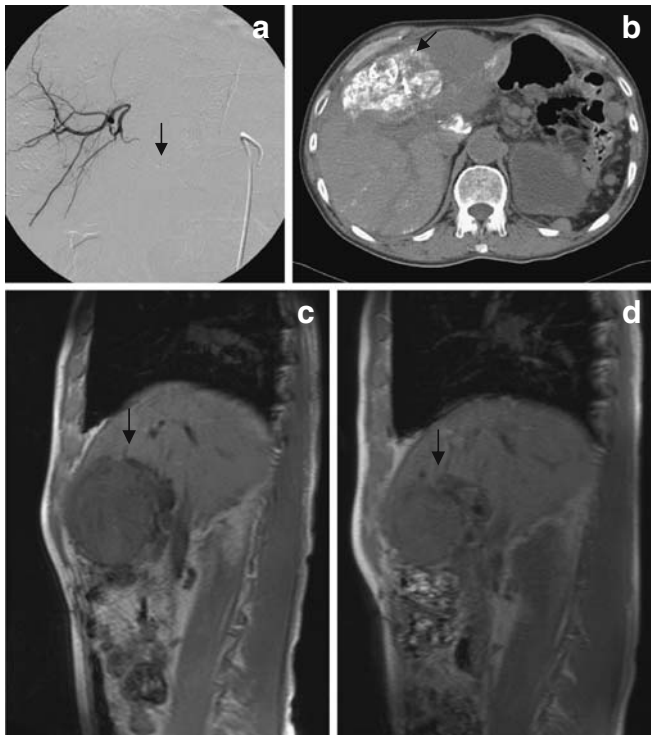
A 51-year-old female patient showing stable disease after TACE. a Hepatic arteriogram using a Sos Omni catheter placed in the celiac trunk through which a 3F microcatheter (arrow) was introduced. b Non-contrast CT abdomen showing lipiodol uptake by the largest lesion lying in the left lobe (arrow). c MRI of the liver before starting treatment. Pre-contrast sagittal T1WI showing the same lesion (arrow). d Control MRI sagittal T1WI after four TACE sessions showing a decrease in the lesion size (arrow). However, this was a less than 50% decrease, hence making this a stable disease outcome by RECIST criteria
